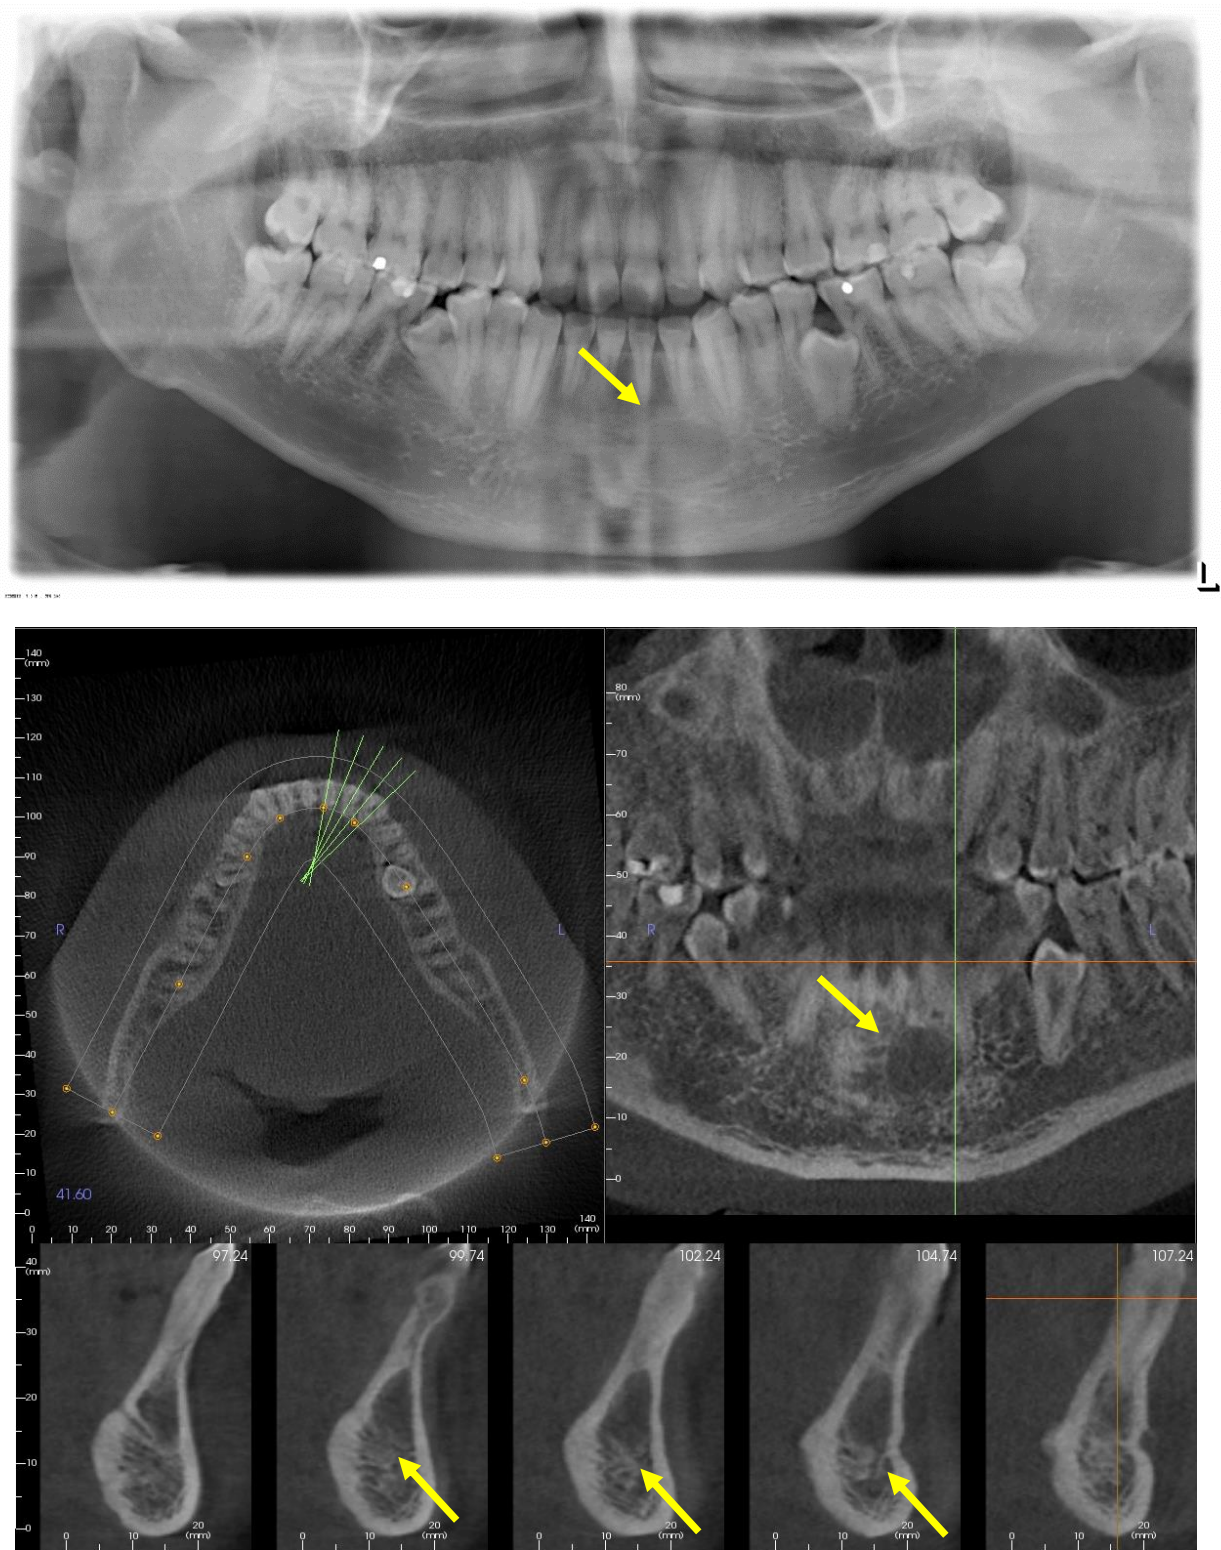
Example of CBCT demonstrating well-defined borders not seen on PAN
